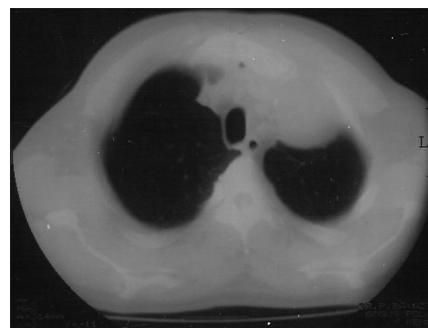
Chest computed tomography imaging of aloculated extrapleural effusion in the left apical hemithorax
